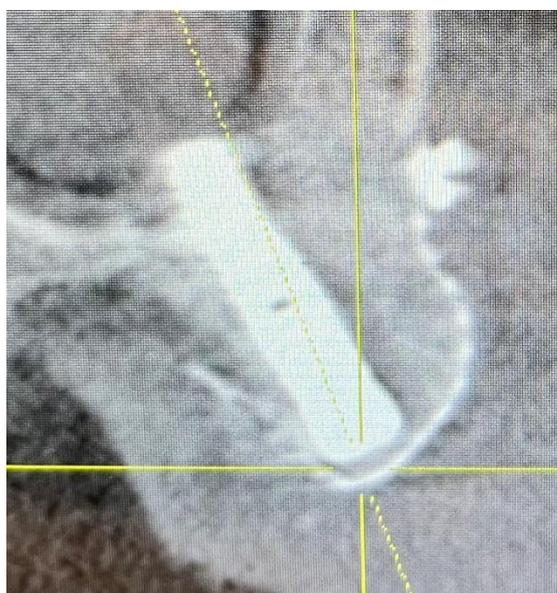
CBCT check bicortical at 6 months*
